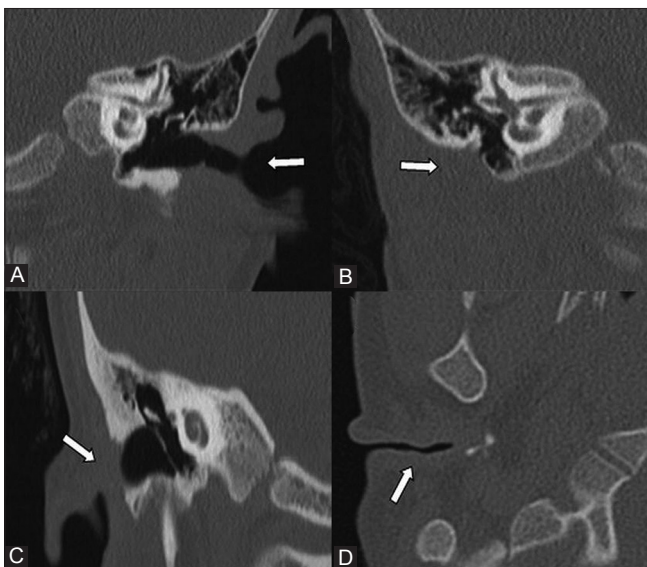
(A-D): EAC anomalies. (A) Coronal HRCT shows EAC with cartilaginous and bony component in a normal ear (arrow). (B) Coronal HRCT of grade I microtia shows combined cartilaginous and bony EAC atresia (arrow). (C) Coronal HRCT shows isolated atresia of cartilaginous EAC (arrow). (D) Axial HRCT section shows stenotic cartilaginous EAC (arrow)
